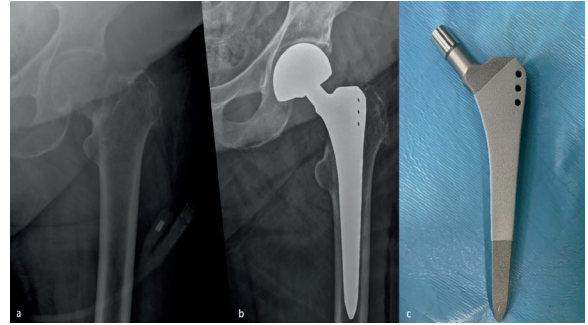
Radiographs of an 84-year-old woman with proximal femur fracture a) preoperative anteroposterior view b) early anteroposterior postoperative radiographs, hemiarthroplasty was performed with a rectangular stem c) photo of rectangular stem
